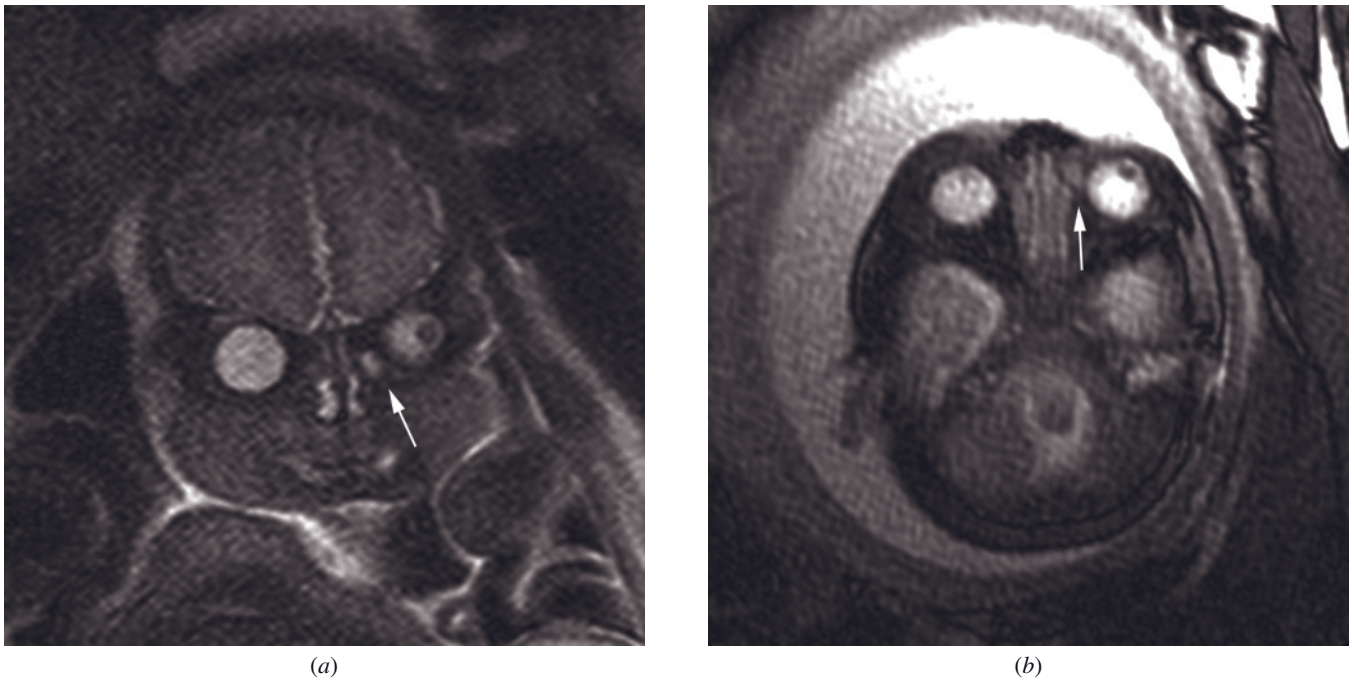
Dacryocystocele. Sagittal (a) and transverse (b) T2-weighted SS-ETSE images of the fetal head demonstrate a well-circumscribed, T2 hyperintense cyst at the inferomedial aspect of the left orbit, consistent with a dacryocystocele, confirmed at birth.
